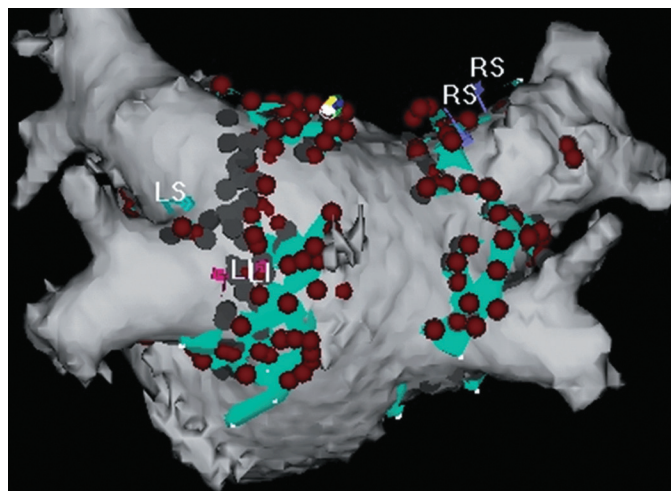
Electroanatomic map of the left atrium merged with a computed tomography scan of the left atrium and pulmonary veins. The red and gray tags indicate the sites at which radiofrequency energy was delivered in the antrum of the pulmonary veins. LI = left inferior pulmonary vein; LS = left superior pulmonary vein; RS = right superior pulmonary vein.
